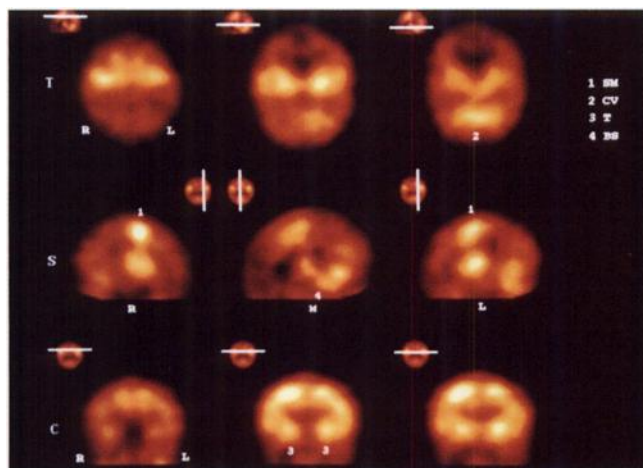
Normal neonatal rCBF pattern (Patient 3). Three representative slices of transverse (T), sagittal (S) and coronal (C) planes depict symmetrical rCBF, highest in the sensorimotor (SM) cortex, thalamus (T), brain stem (BS) and cerebellar vermis (CV). Note physiologically low rCBF in the frontal, parietal and temporal cortices. US and MRI were unremarkable. Small reference images with a straight line depict tomographic level of each slice. Sagittal slices through the right (R), left (L) and mid-line (M) are shown.
